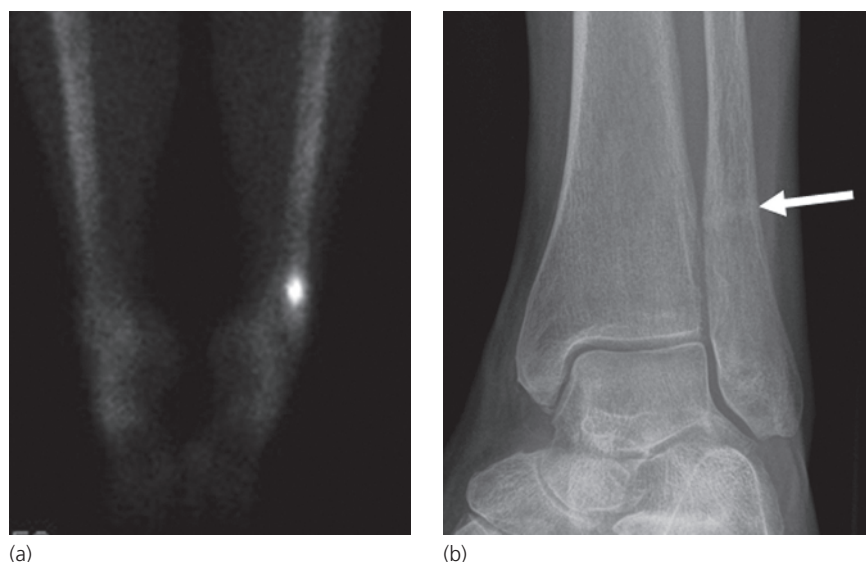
Bone scan in an insufficiency fracture. (a) Static image from the bone scan shows focal increased activity in the left distal fibula. (b) Radiograph confirms the fracture evident by linear sclerosis in the distal fibular shaft (arrow).
